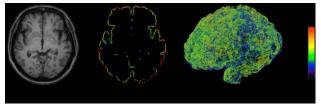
Color-coded map of cerebral cortical thickness for a CN case produced by the proposed method: (a) an original MR image, (b) an axial image, (c) a 3D image.
